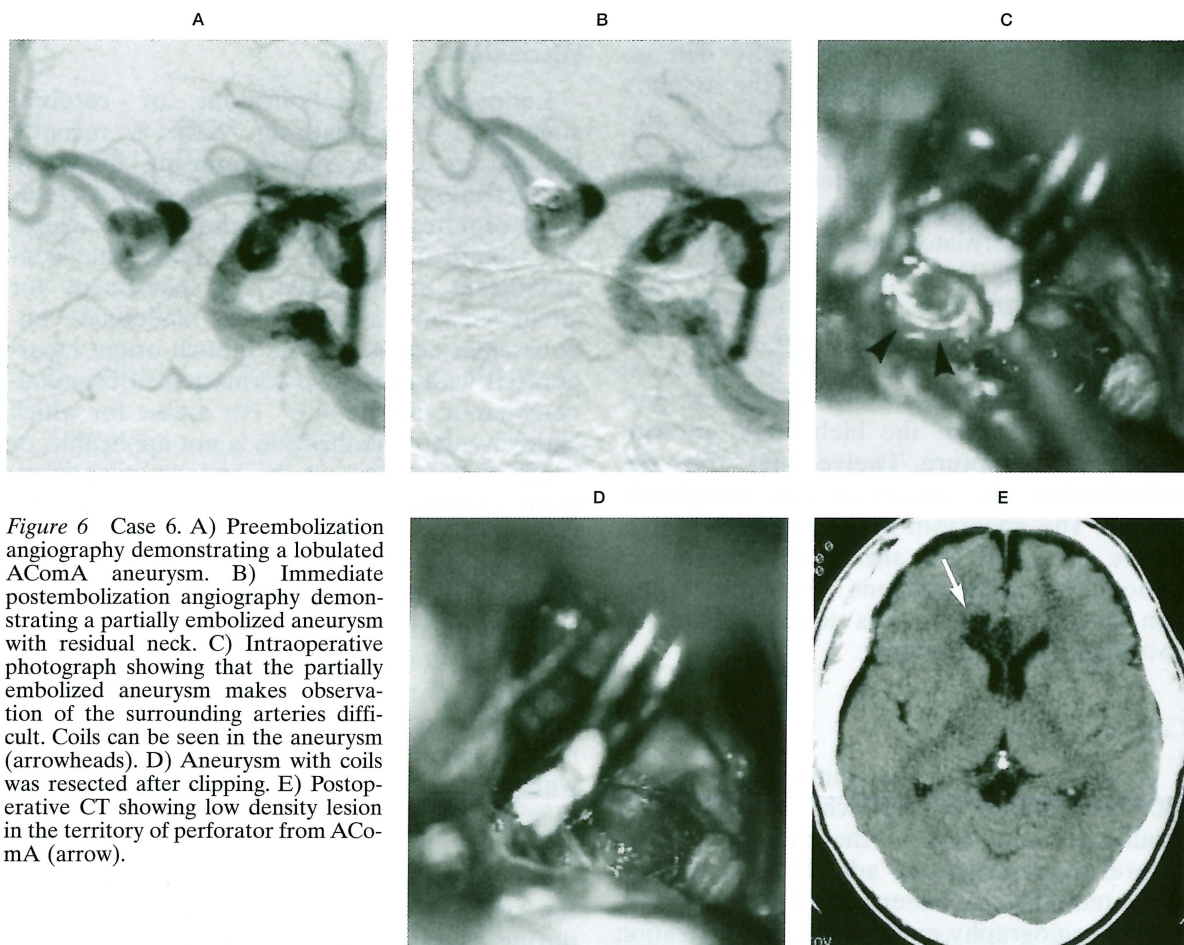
Case 6. A) Preembolization angiography demonstrating a lobulated AComA aneurysm. B) Immediate postembolization angiography demonstrating a partially embolized aneurysm with residual neck. C) Intraoperative photograph showing that the partially embolized aneurysm makes observation of the surrounding arteries difficult. Coils can be seen in the aneurysm (arrowheads). D) Aneurysm with coils was resected after clipping. E) Postoperative CT showing low density lesion in the territory of perforator from AComA (arrow).
